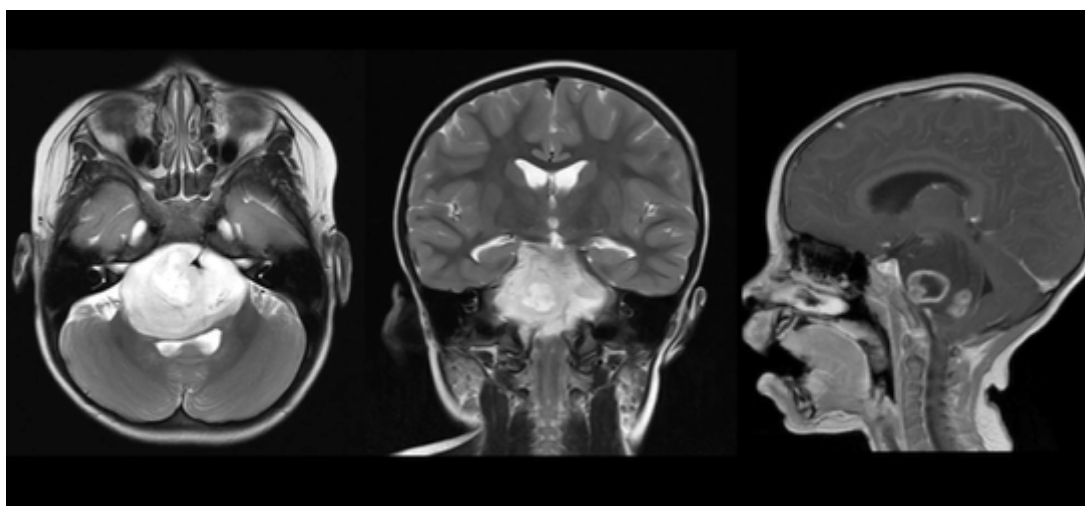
MRI imaging of the patient.
